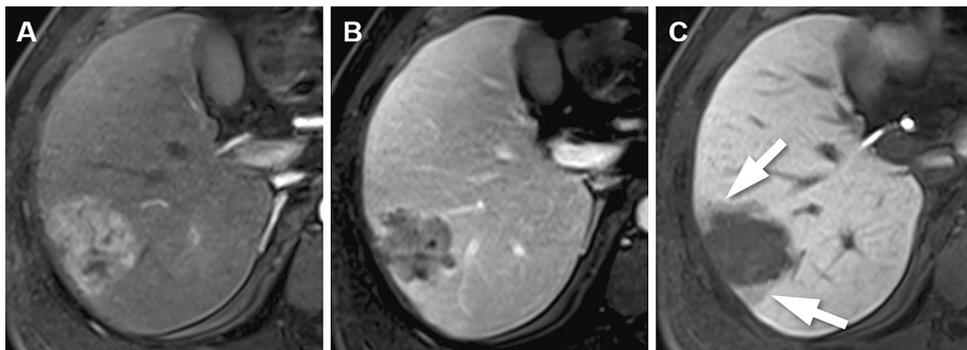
Hepatocellular carcinoma with peritumoral arterial phase hyperenhancement in a 64-year-old woman. In the arterial phase of gadoxetate-enhanced MRI (A), a 4.5-cm mass in right liver shows diffuse hyperenhancement along with peritumoral
